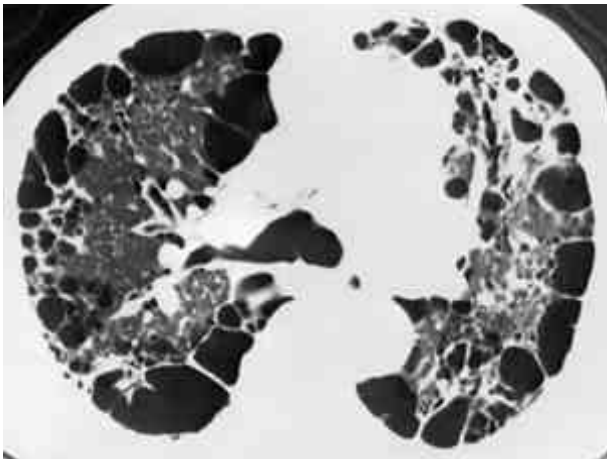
High-resolution CT of a 66-year-old man with idiopathic pulmonary fibrosis shows typical honeycomb pattern distributing mainly at subpleural area.
